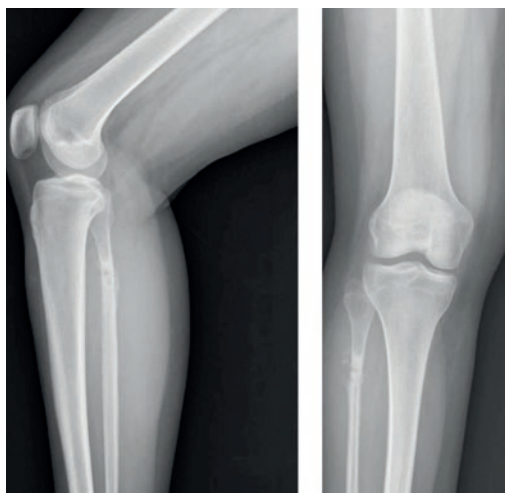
Plain radiographs of the fibula at baseline (February 2020).
